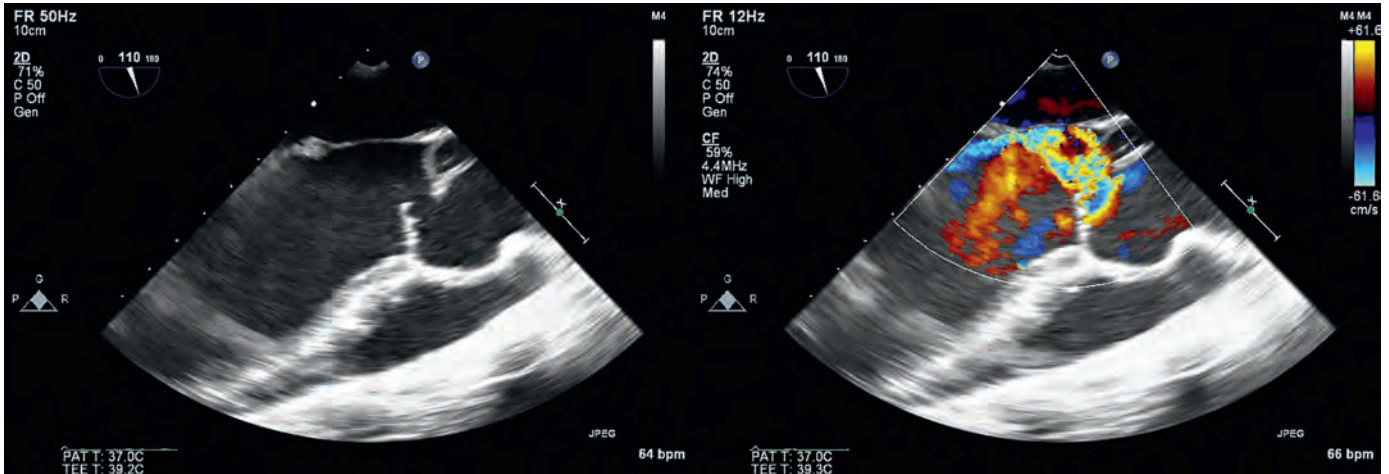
Type II aortic regurgitation. Midesophageal aortic valve long-axis view demonstrates (left) the right coronary cusp (most anterior) prolapsing into the left ventricular outflow tract. (Right) Addition of color-flow Doppler reveals a large posteriorly directed regurgitant jet. An impressive proximal isovelocity surface area shell is seen on the aortic side of the aortic valve. (Video available online.)
